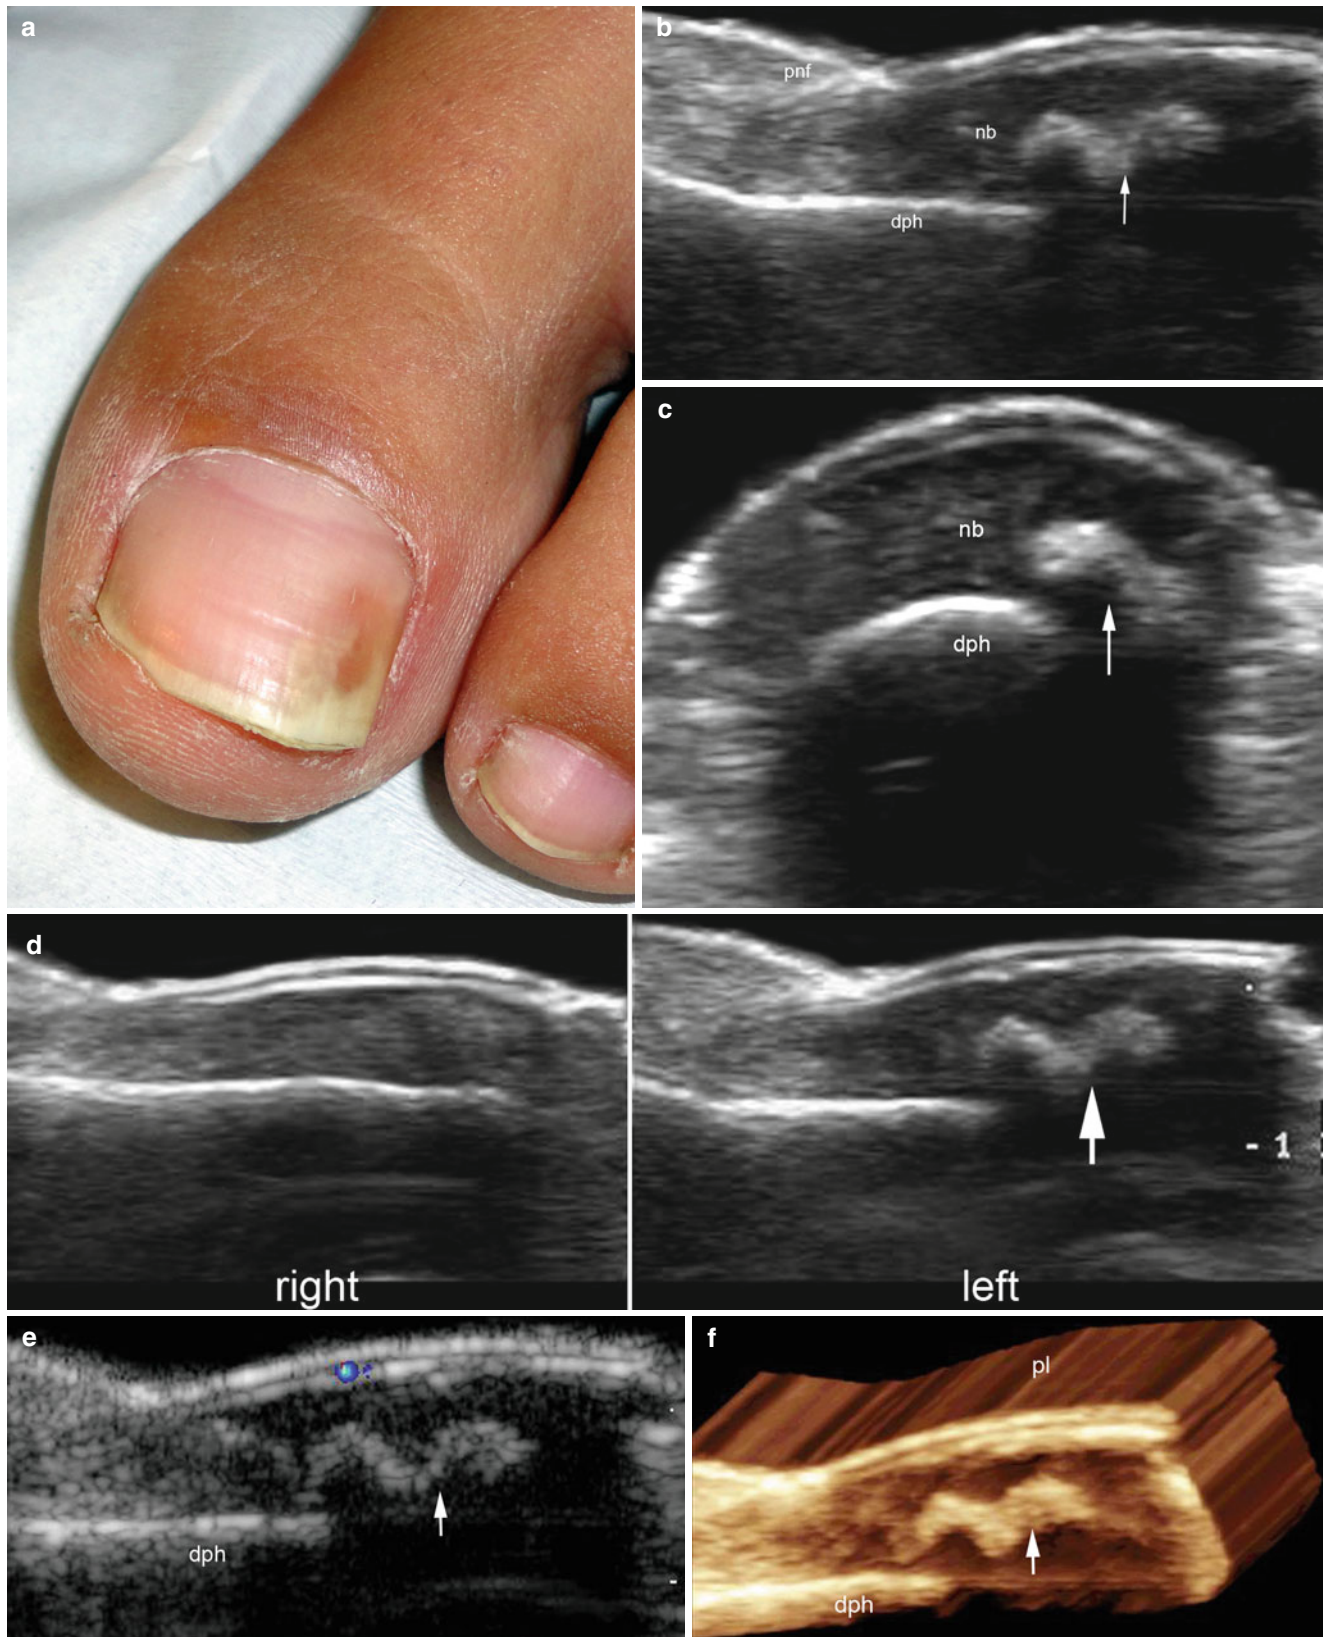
(a–f) Subungual exostosis. (a) Clinical image shows brownish and dystrophic changes in the nail plate of the left hallux. Tests for onychomycosis were negative for the previous 4 months. (b, c) Grey scale ultrasound images (b longitudinal view; c transverse view) show a wavy hyperechoic band (arrow) in the lateral aspect of the nail bed that produces posterior acoustic shadowing. (d) Grey scale ultrasound image (longitudinal view, side by side comparison) shows an
